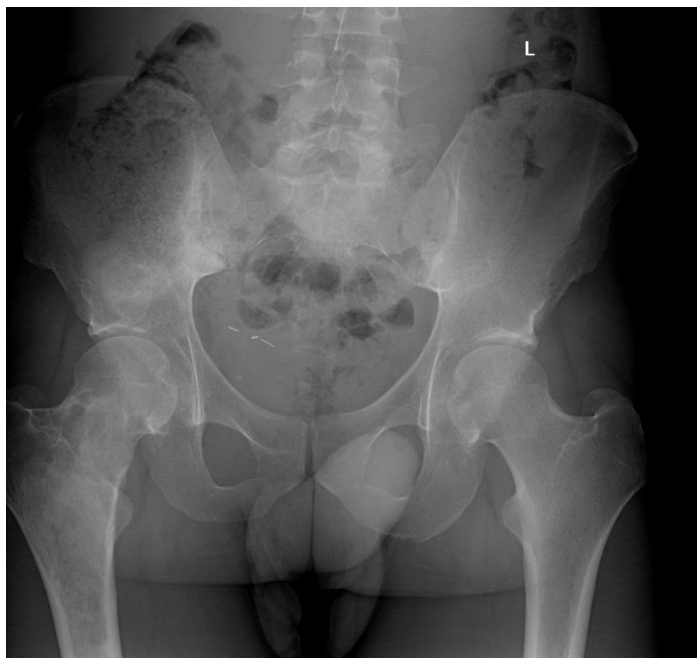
Pelvis radiograph shows lesions which cause moderate cortical thinning with endosteal irregularity. There is no associated periosteal reaction or soft-tissue mass. Similar lesions are present within the right ilium in the supra-acetabular region. The right femoral neck demonstrates a focal expansive lytic lesion with important cortical thinning. Sclerosis of the ilium adjacent to the sacroiliac (SI) joints is also identified.
